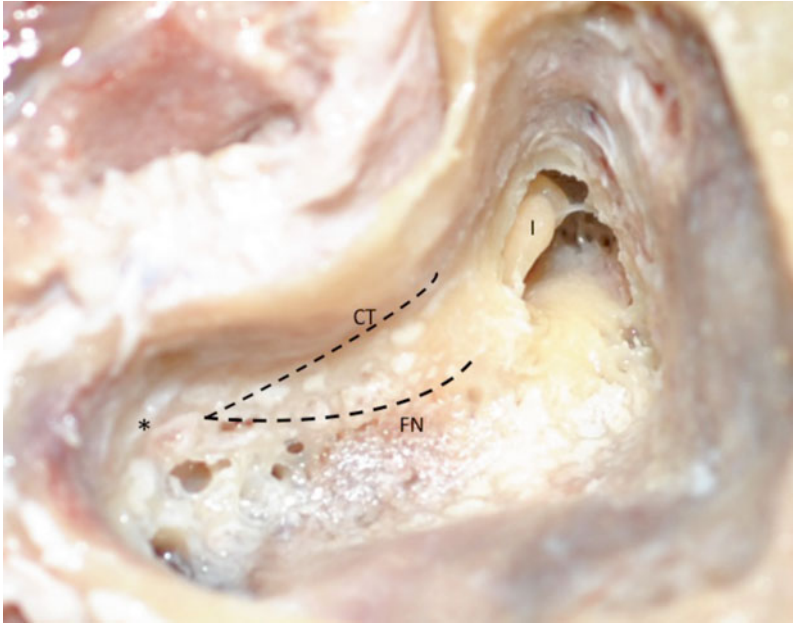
Imaginary course of the facial nerve and chorda tympani (*CT* chorda tympani, *FN* facial nerve, *I* short process of the incus, *asterisk* digastric ridge)
